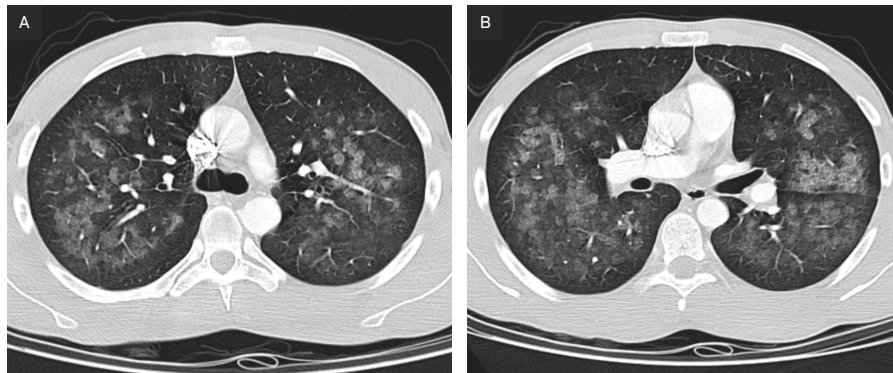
Axial chest CT images at the level of (A) the carina and (B) the main pulmonary artery demonstrating central ground-glass opacities with relative subpleural and lobular sparing.
